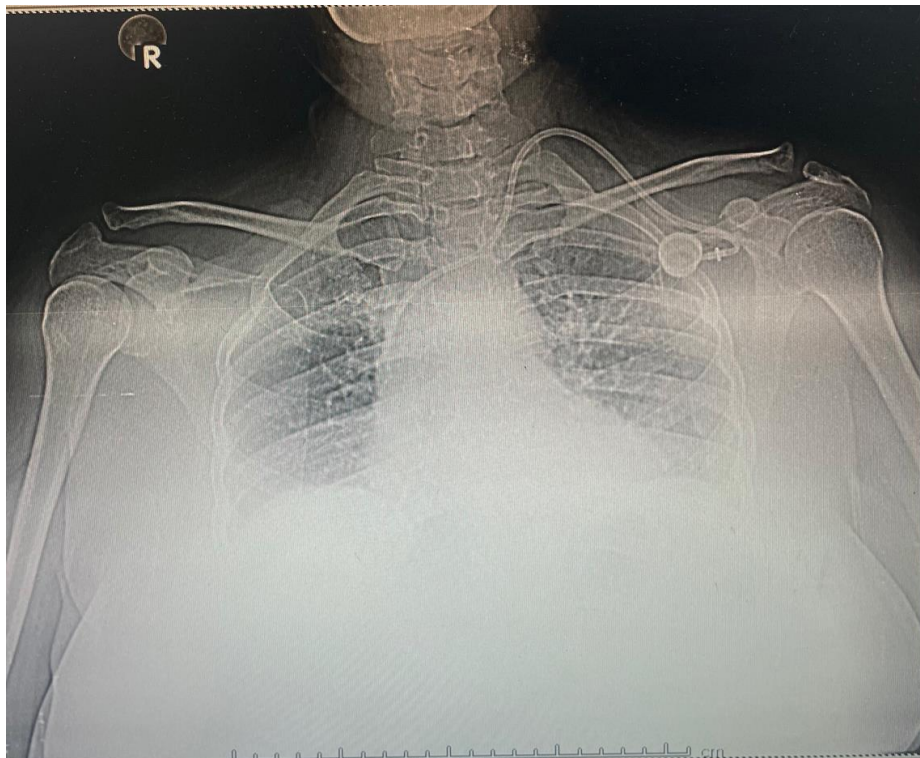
Chest radiograph demonstrating the implanted port system and catheter course.
